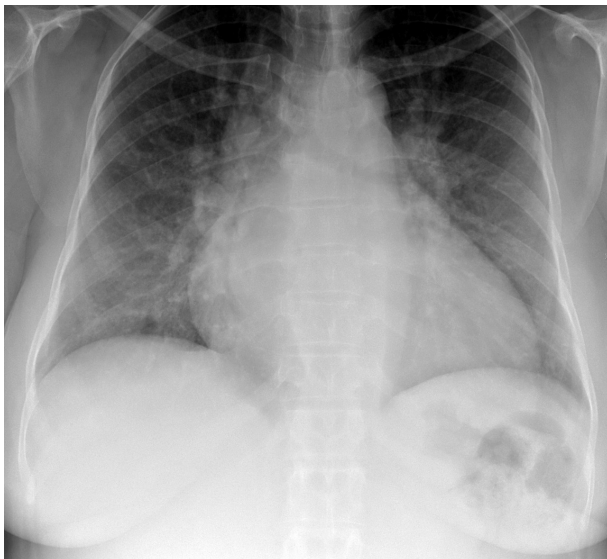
Chest radiography shows bilateral hilar enlargement, which is a typical finding in patients with pulmonary arterial hypertension, as well as cardiomegaly.
